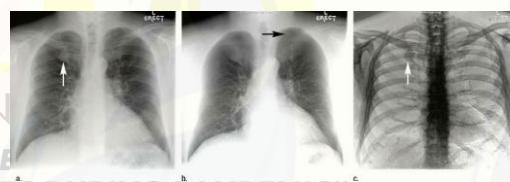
Dual-energy subtraction radiography in a healthy middle-aged man
